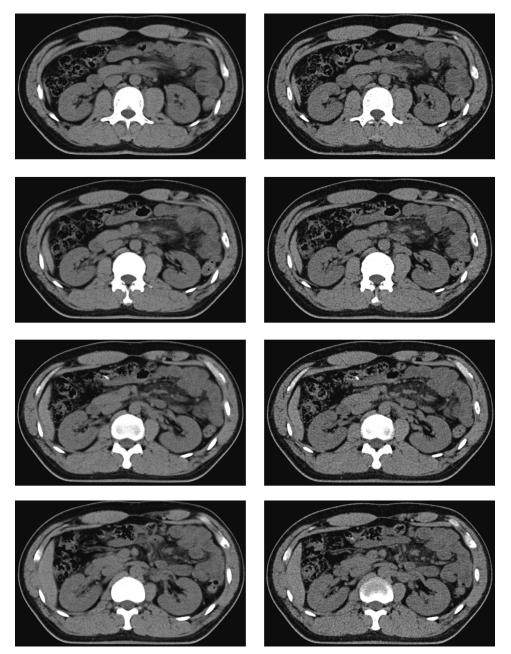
Abdominal CT image showing well-limited densification of the mesenteric fat or misty mesentery.
